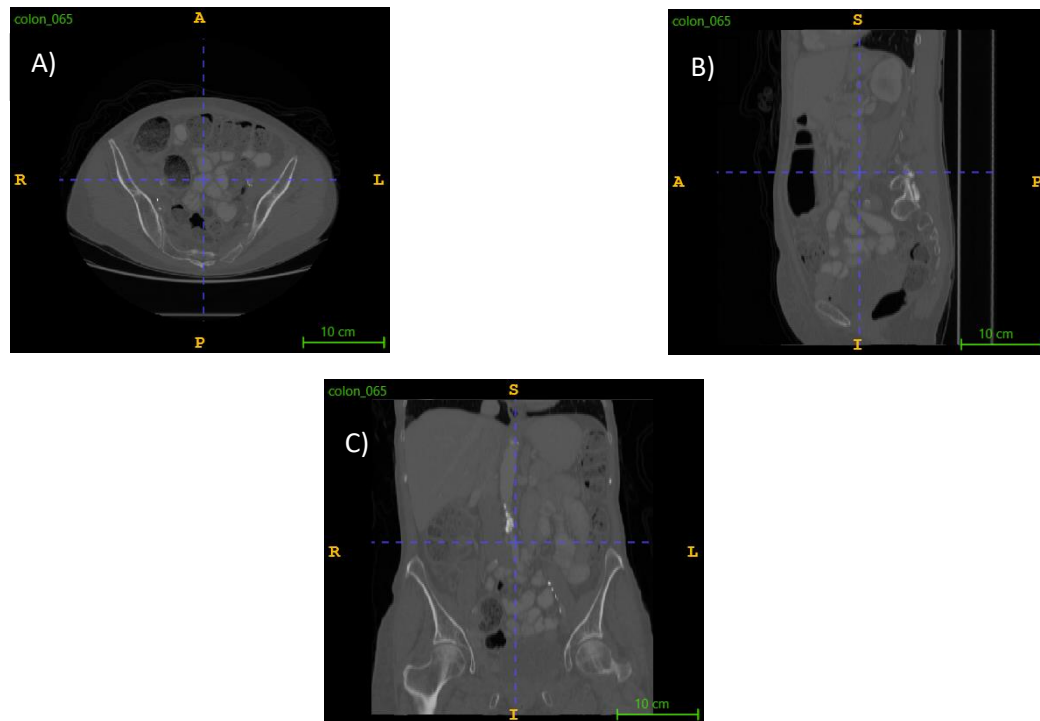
Sample images taken from colon_040 nifti file sample of a CT scan from Medical Decathlon Segmentation website, there were screenshot by ITK-SNAP app, (a) Axial display, (b) Sagittal display, and (c) Coronal display.
